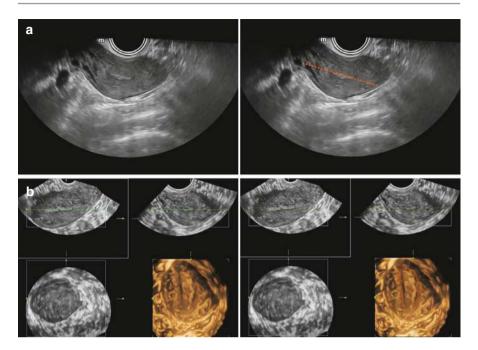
(a) The uterus appears small in transverse diameter, with only one well-developed uterine horn. The transverse uterine diameter is highlighted in orange. (b) A coronal view of the uterine cavity in 3D ultrasound reveals a tubular shape. The tubular uterine cavity is outlined in orange
